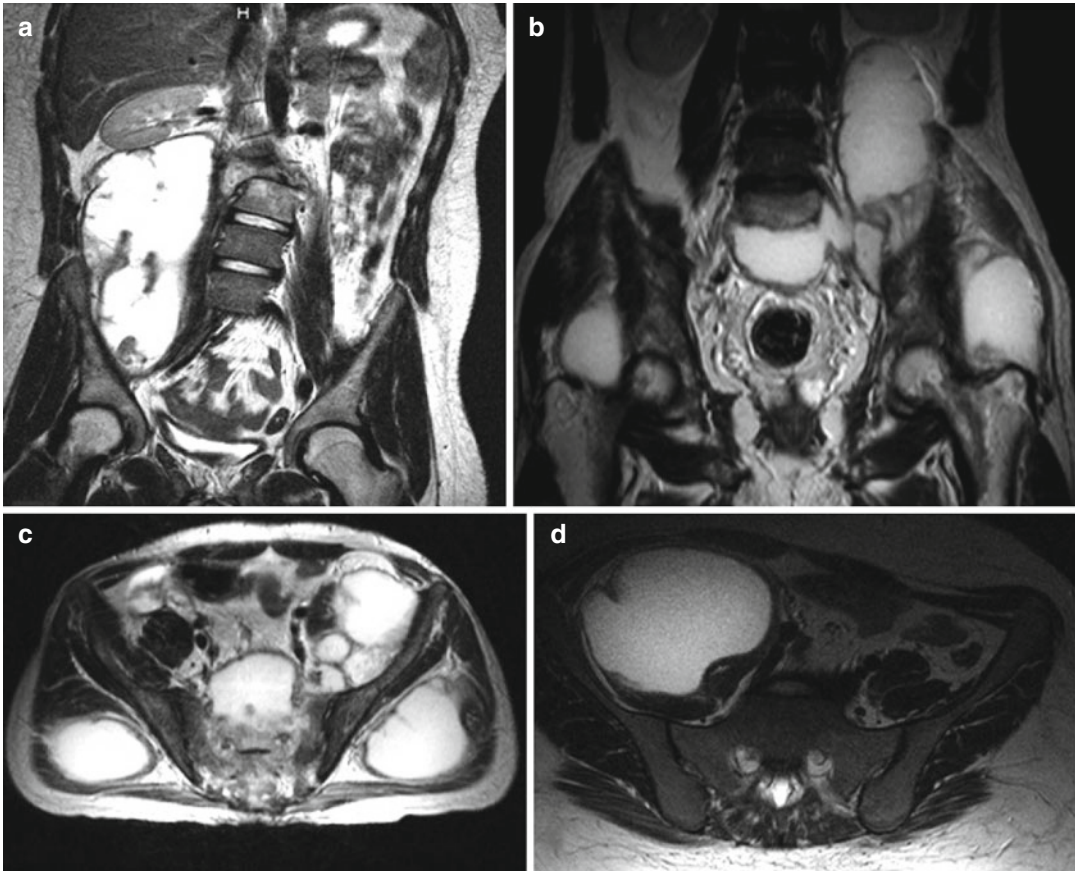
Tubercular cold abscess can be present in multiple locations depending on the pathway of its spread across areolar spaces. In this 40-year-old patient, who presented with back and bilateral gluteal pain, extensive cold abscess formation was observed. Coronal T2 MRI sections of the lumbar
